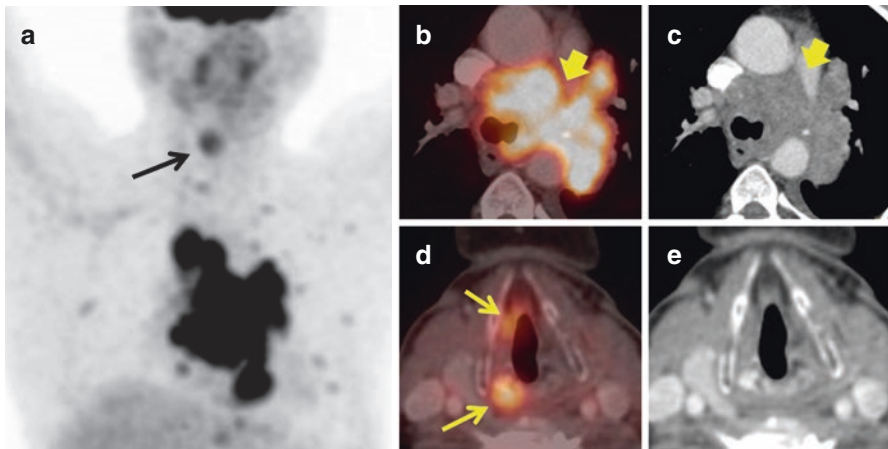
FDG PET/CT scan of a 58-year-old gentleman with carcinoma in the upper lobe of the left lung. MIP and transaxial images (a–c) show a large FDG-avid mass in the left upper lobe infiltrating the mediastinum and involving the aortic pulmonary window (block arrows in b, c) through which the left recurrent laryngeal nerve traverses thereby involving it and causing paralysis of the left vocal cord. This in turn causes compensatory hypertrophy of the contralateral (right) vocal cord seen as increased FDG uptake in the right vocal cord and cricoarytenoid muscle (arrows in a, d)
